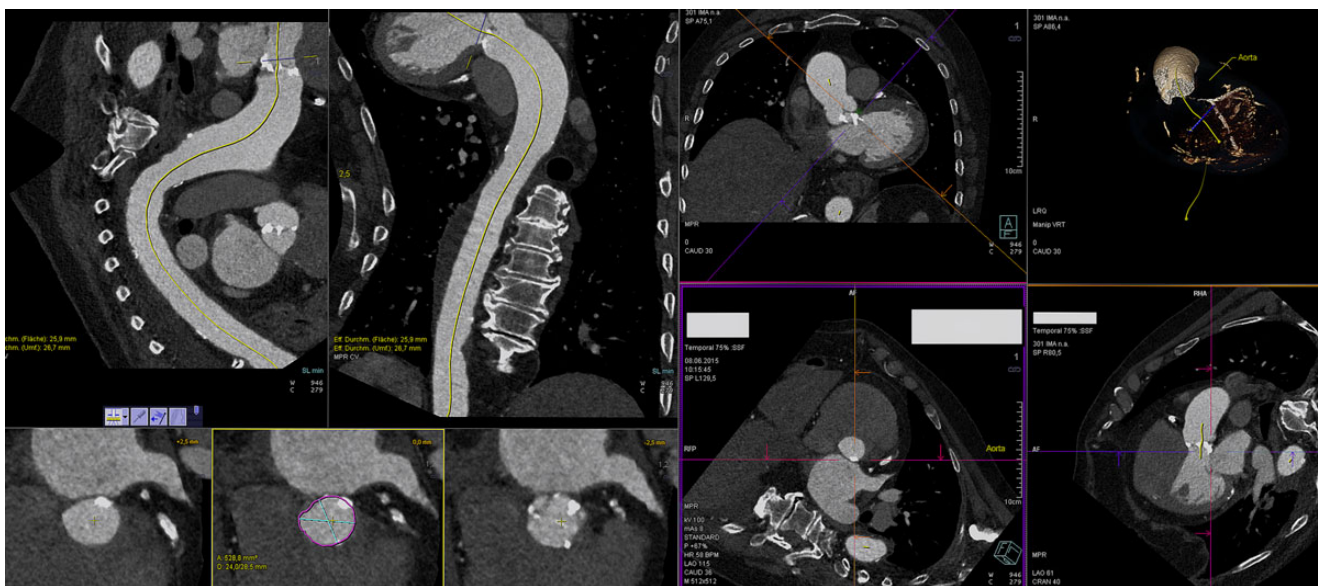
Computed tomography-based analysis of subannular calcifications using *syngo.via* software.
